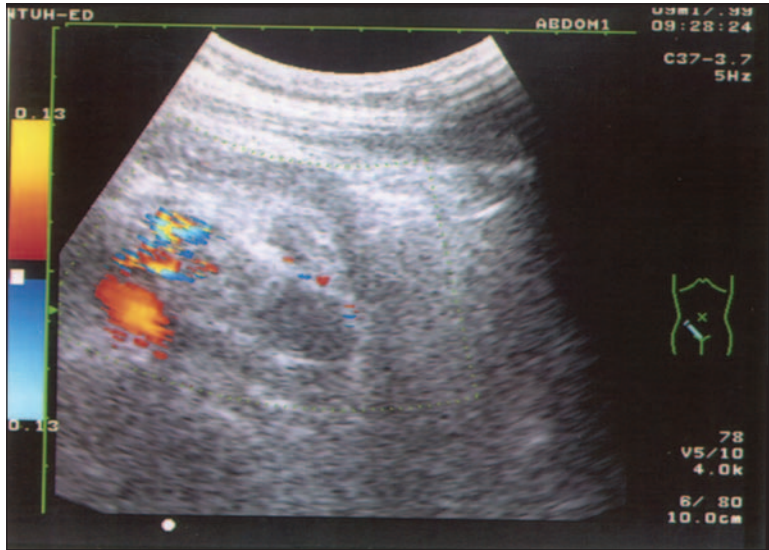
Color Doppler sonography shows increase vascularity over lower appendiceal wall.
